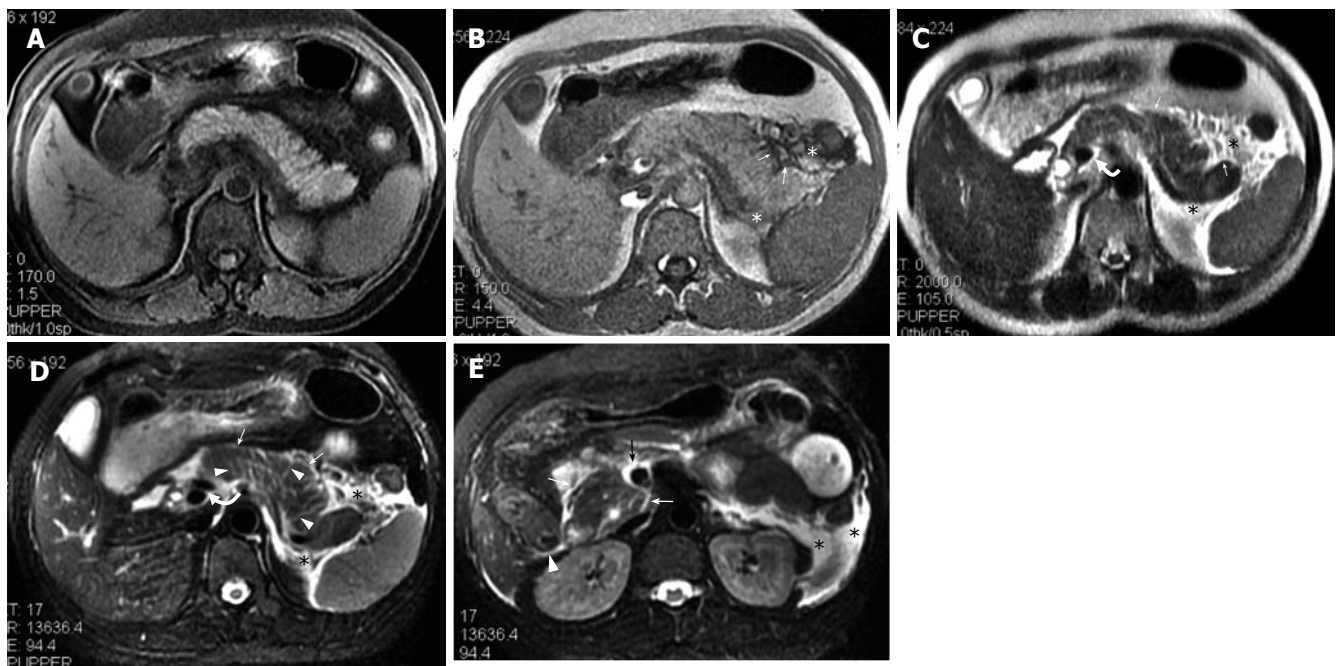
A 28-year-old man with IEP. A: SPGR fat-suppressed T1-weighted (TR/TE = 170/1.6 ms) image shows normal pancreatic signal intensity; B: pancreatic fascial (arrows) and peripancreatic fat (asterisk) stranding can be seen on GRE in-phase (TR/TE, 150/4.4 ms) image; C: SSFSE T2-weighted (TE = 90 ms) image; D: R-T T2-weighted (TR/TE = 12300/98 ms) image. Perivascular fluid (curve arrow) can be seen on latter two sequences. Thickened pancreatic lobular septum (arrow heads) can only be seen on R-T T2-weighted image (D); E: At the level of the head of the pancreas, R-T T2-weighted image (E) shows pancreatic fascial plane (white arrow), right renal fascia plane (white arrow head), fluid surrounding SMV (black arrow), and left anterior pararenal space and lateroconal plane fluid collections (asterisk).
